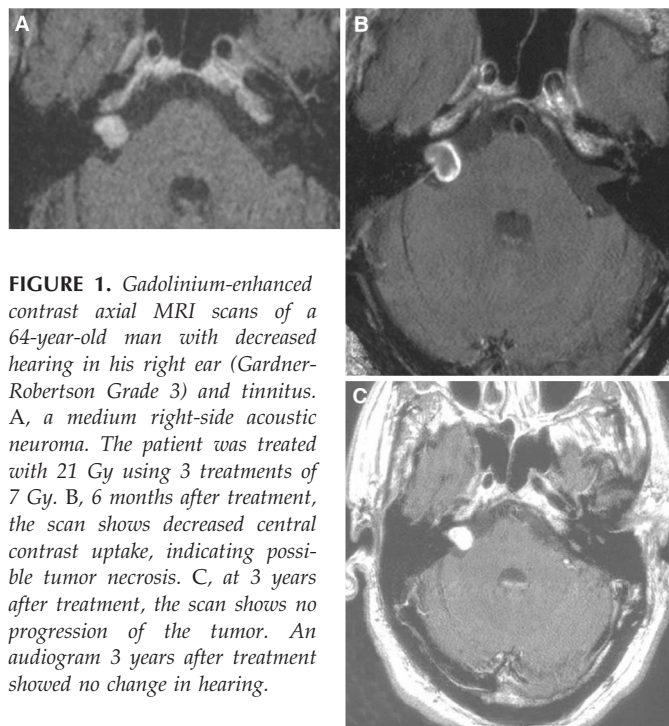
Gadolinium-enhanced contrast axial MRI scans of a 64-year-old man with decreased hearing in his right ear (Gardner-Robertson Grade 3) and tinnitus. A, a medium right-side acoustic neuroma. The patient was treated with 21 Gy using 3 treatments of 7 Gy. B, 6 months after treatment, the scan shows decreased central contrast uptake, indicating possible tumor necrosis. C, at 3 years after treatment, the scan shows no progression of the tumor. An audiogram 3 years after treatment showed no change in hearing.
